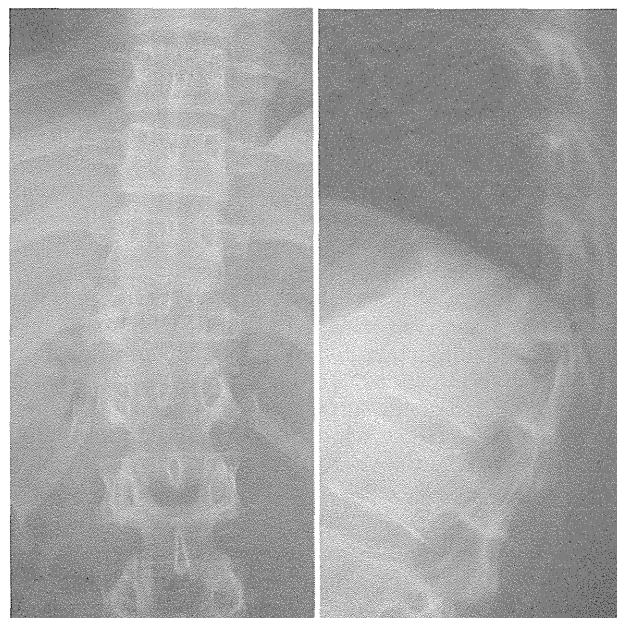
Plain radiographs showing deteriorated local kyphosis (Cobb angle 50°).
